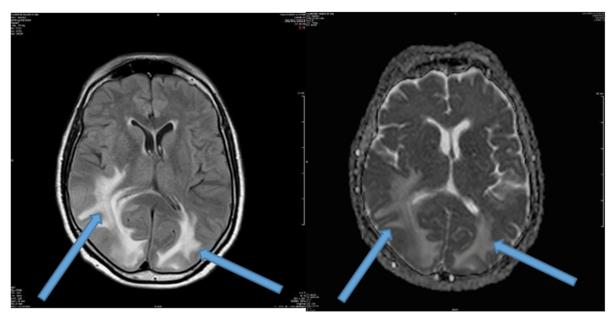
FLAIR and ADC from january 26, 2023.
